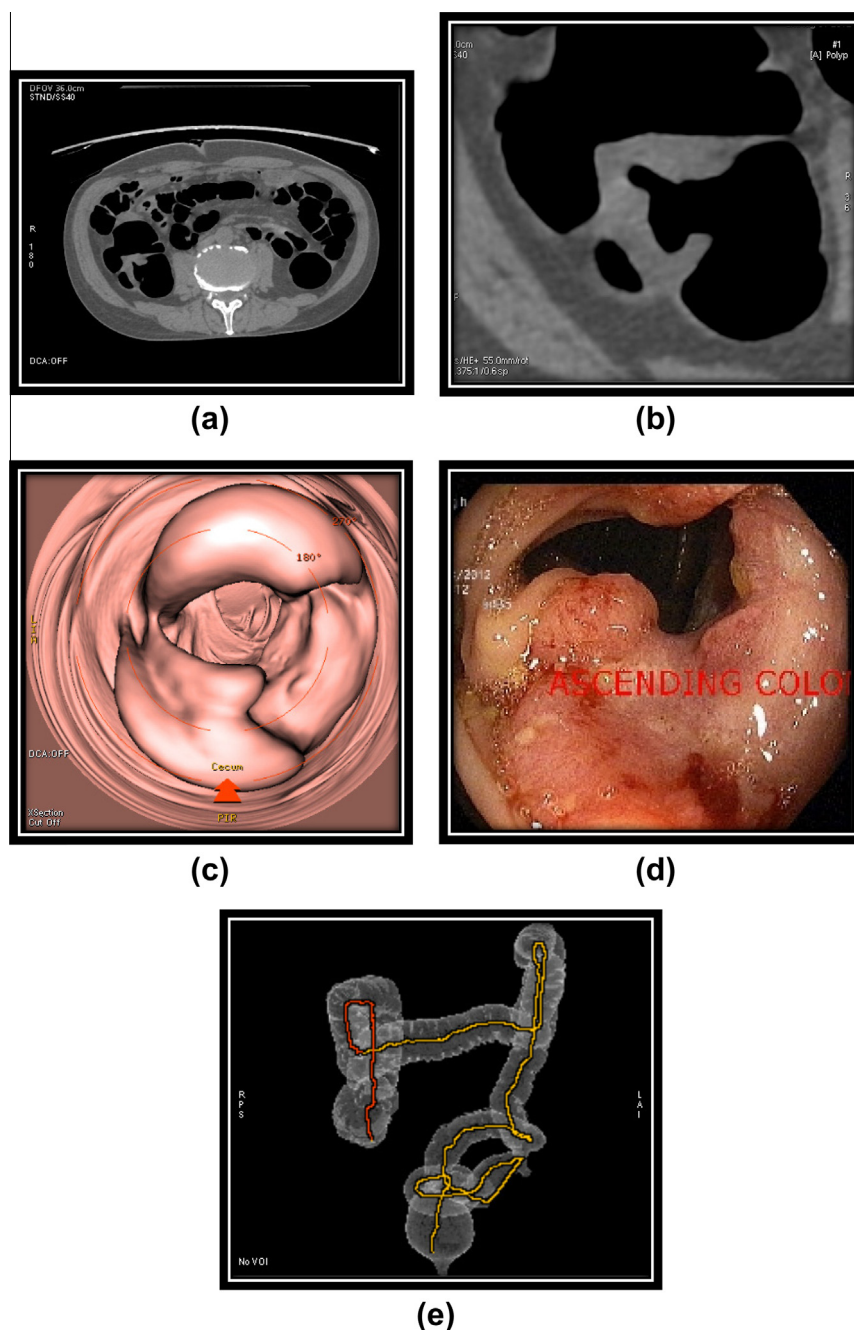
Well differentiated adenocarcinoma in a 65-year-old male. (a) Axial (prone) CT colonoscopy image showing irregular thickening of the haustra in the ascending colon. (b) Transverse 2D MPR shows better appreciation of the growth. (c) Endoluminal view of Virtual Colonoscopy showing growth involving the ascending colon. (d) Confirmation of growth involving the ascending colon in the optical colonoscopy (e) Volume rendered image depicts lesion in the ascending colon.
